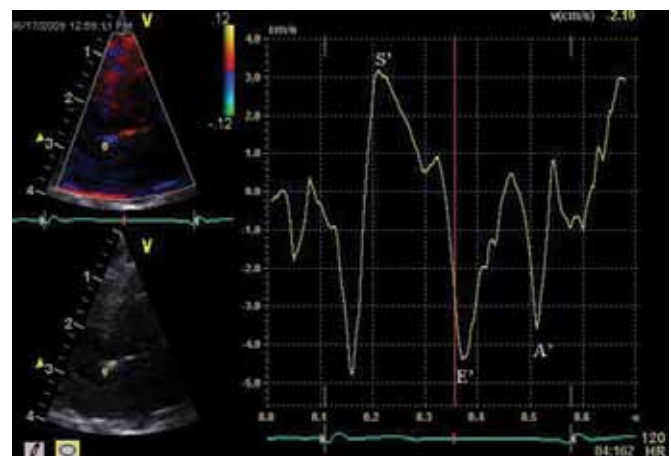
Apical 4-chamber view TV (upper left) with Q-wave analysis (right) obtained from a 1-mm sample area at the septal wall (yellow dot). Peak systolic (S'), peak early diastolic (E'), and peak late diastolic (A') velocities are noted.
